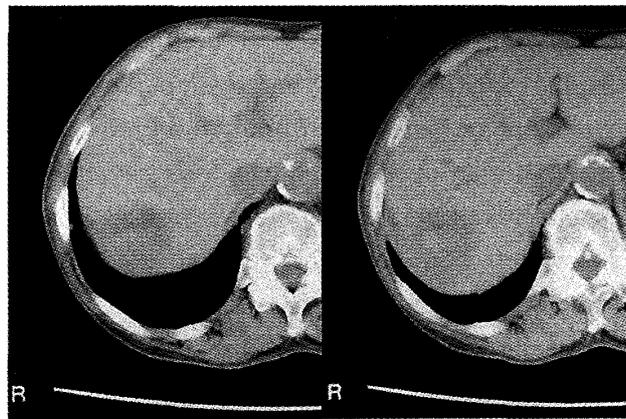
Abdominal CT: An abdominal CT scan showed a tumor measuring 3cm in diameter in the posterior superior sub-segment of the right lobe of the liver.
